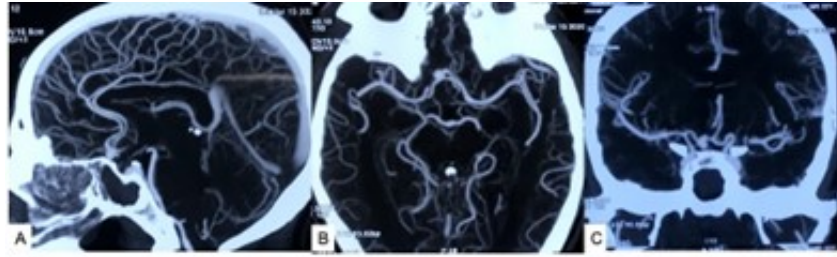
CTA of brain (showing the inside of the brain case); (A–C)—sagittal, axial, and coronal views, respectively, showing an ACOM aneurysm with otherwise normal vasculature. Source: Figure by authors.
